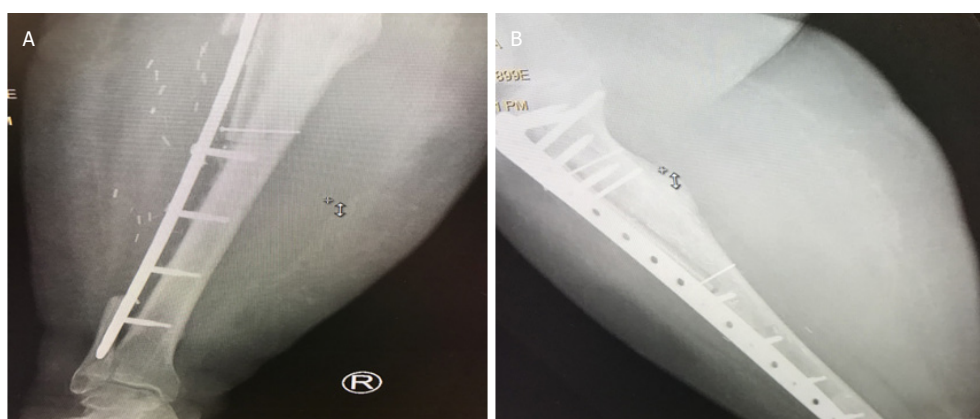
Radiographs demonstrating bony union following pedicled fibula reconstruction
